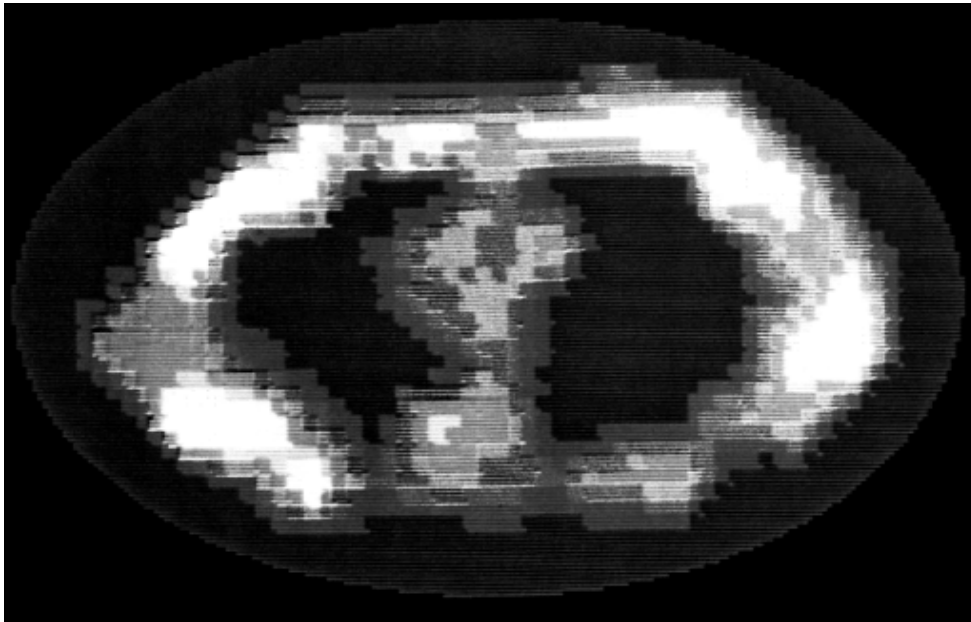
First MRI body image recorded by Goldsmith et al. By today's standards this image has an extremely low (coarse) resolution, however, basic structures like the heart and lungs are visible in the image.
